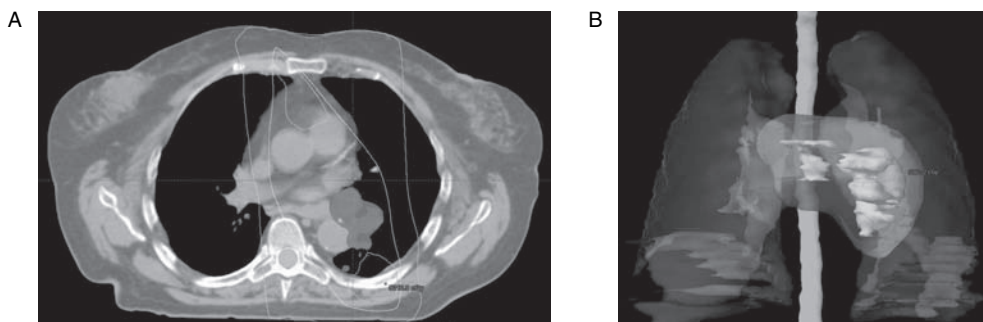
A. Dosimetric plan used for L-SCLC: AP: PA fields and opposed oblique fields (off the spinal cord). Doses shown are 48, 45, and 20 Gy. B. A dose cloud of 45 Gy is shown surrounding all gross disease detectable on PET/CT. Gross tumor received 45 Gy in 30 twice-daily fractions and the spinal cord received no more than 36 Gy.
